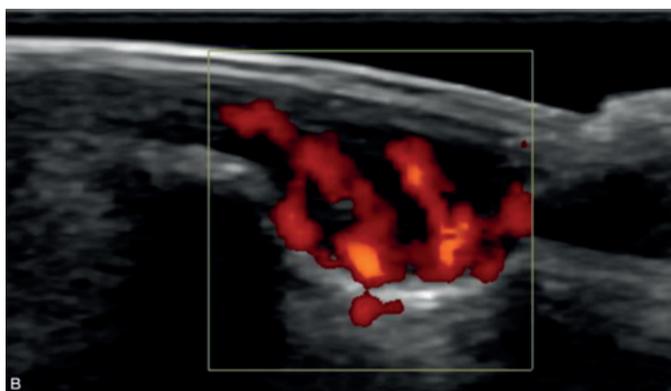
Power Doppler assessment – signs of hypervascularization of the lesion (red).
